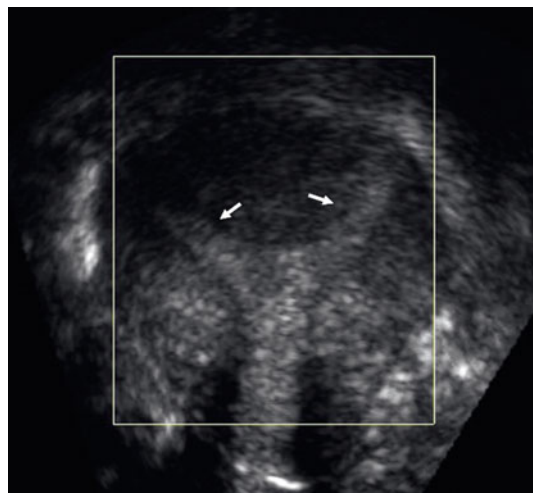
Bicornuate uterus. 3D sonogram shows the double uterine cavity (*arrows*) with a single cervix
